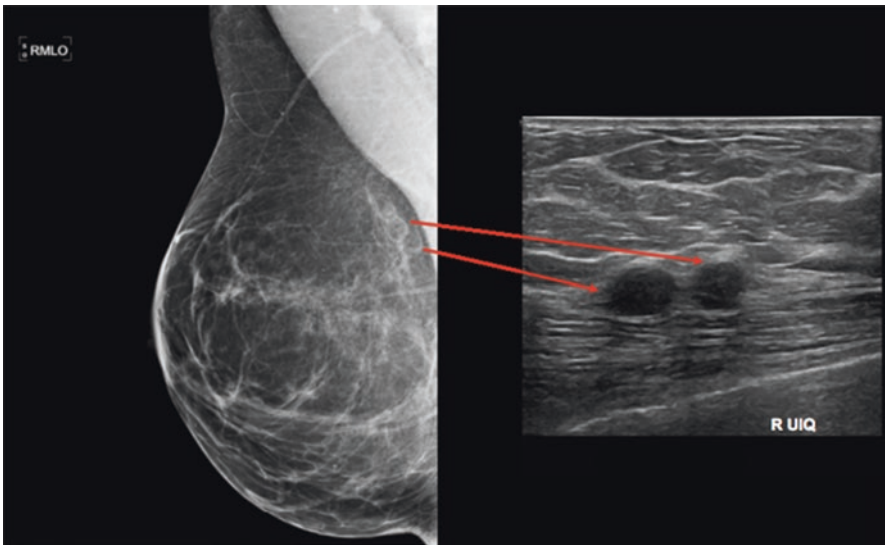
Oily cysts in the posterior third of the right breast seen on mammography and their correspondence in the ultrasound study, next to the pectoral muscle
